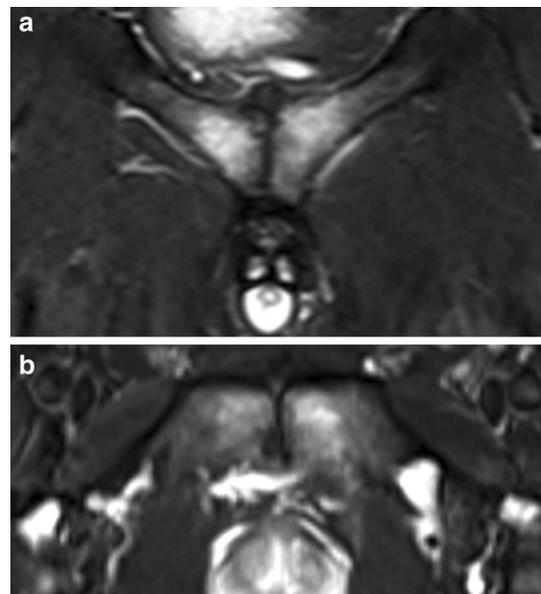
a, b Osteitis pubis in an amateur football player (MRI, T2 stir, coronal and axial plane): bilateral bone bruise around the symphysis joint
